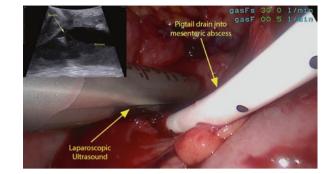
Laparoscopic ultrasound-assisted drainage of deep abscess in abdomen
